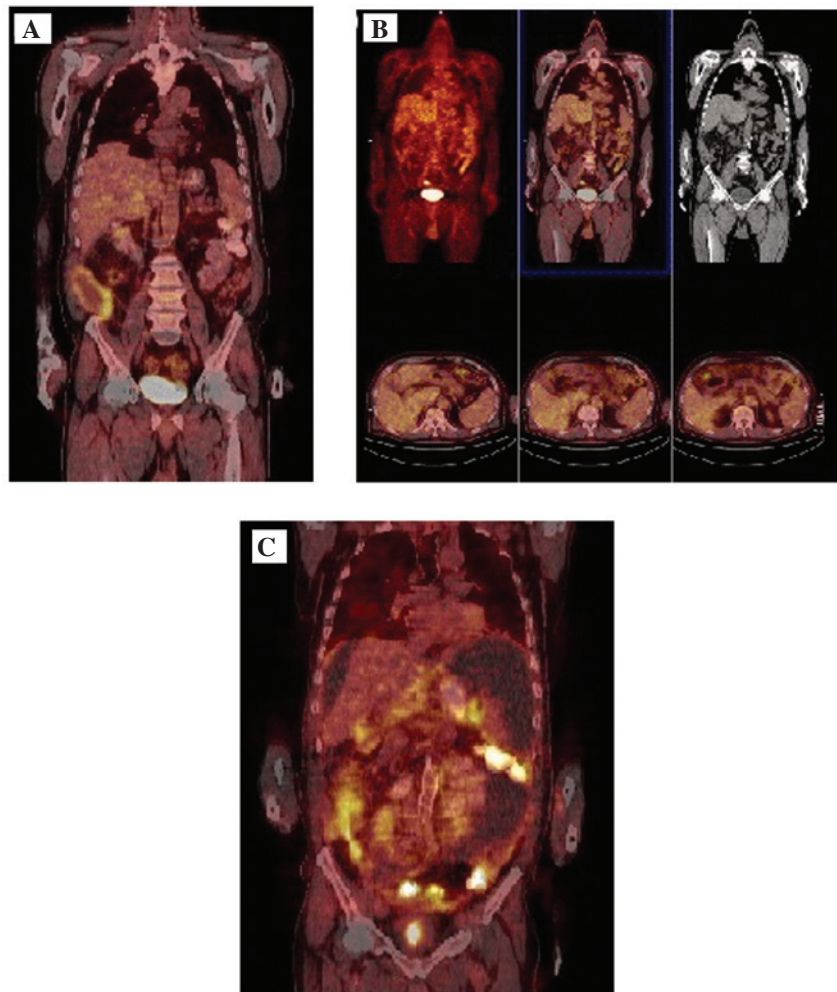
(A) Post-operative PET-CT scan demonstrating the presence of a hypermetabolic lesion in the right lower abdomen. (B) PET-CT scan demonstrating the presence of hypermetabolic lymph nodes in the abdomen. (C) Extensive peritoneal involvement following treatment for follicular lymphoma. PET-CT, positron emission tomography-computed tomography.
